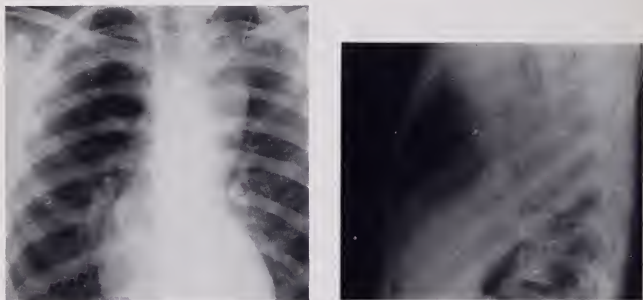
Patient C. C. Postero-anterior and lateral roentgenograms of the chest showing a midmediastinal soft tissue density extending to the left of the spine.
